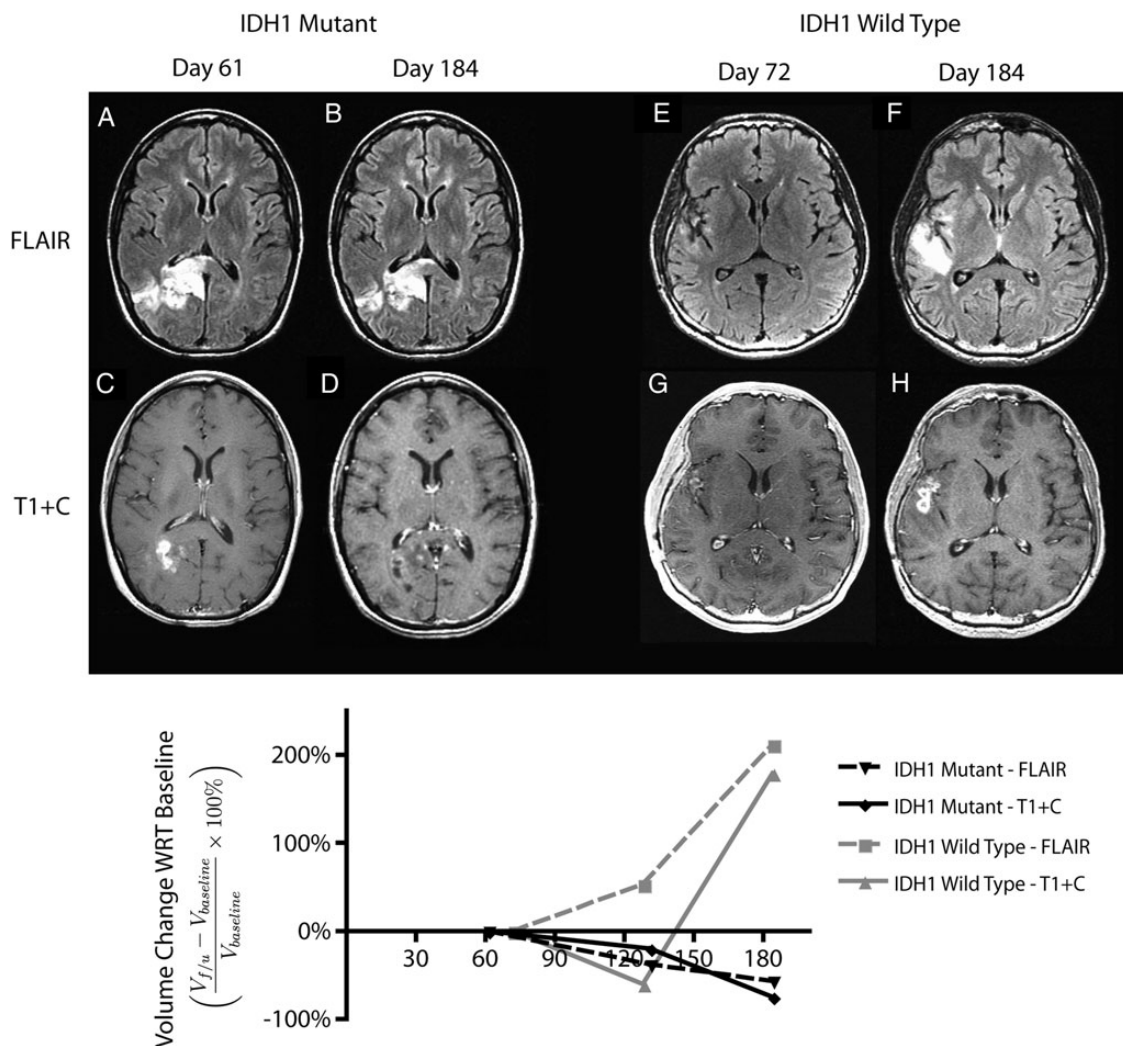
Radiographic changes and serial volumetric analysis of a responder and nonresponder to radiochemotherapy regime. All MR images were dated with regard to the start date of radiotherapy. Baseline volumes of T2/FLAIR hyperintense region (V_{FLAIR}) and contrast-enhancing tumor (V_{T1+C}) were measured from the first scans postradiotherapy (A, B: IDH1 mutant case and E, F: IDH1 wild-type case). Tumor kinetics were estimated by measuring the relative changes of the region of interest in subsequent scans (C, D: IDH1 mutant case and G, H: IDH1 wild-type case) with regard to the baseline volume. I: The relative volumes were presented as a function of time. Dashed lines denote the trend in V_{FLAIR} . Solid lines denote the trend in V_{T1+C} .
